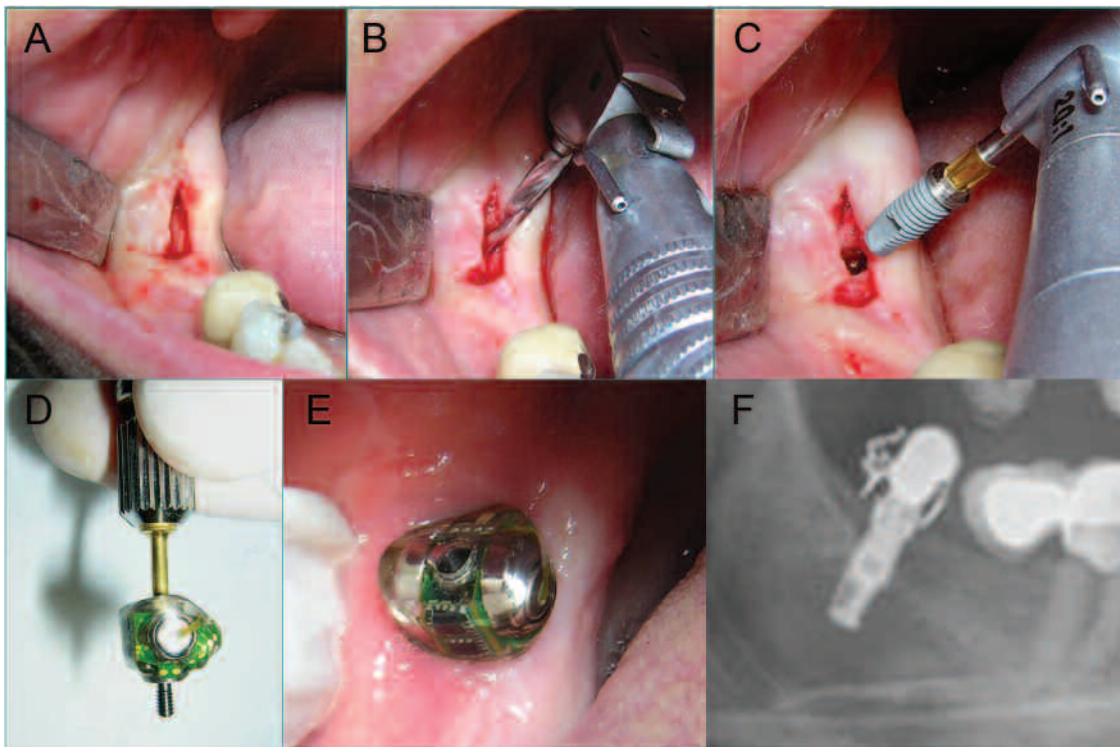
Third-generation implant-supported neuro-electrostimulating device can be permanently applied into the oral cavity as it can be screwed onto an osteo-integrated dental implant inserted in the third molar area. Figure shows the implantation procedure and application of the device. Transmucosal exposure of mandibular bone (A) is followed by preparation of the implant bed in mandibular bone (B) and insertion of the dental root implant (C). The neuro-electrostimulating device is shown in its applicator (D) and mounted onto the root implant (E). A radiograph of the implant-supported device is shown (F).
